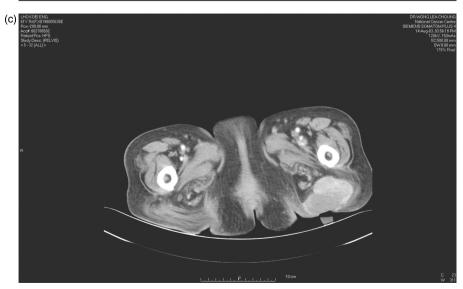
(a) CT demonstrated a pulmonary mass in the right lower lobe and (b) hepatic metastasis. (c) CT scan of the pelvis showed enhancing masses in the gluteus maximus muscle confirming metastatic spread.
